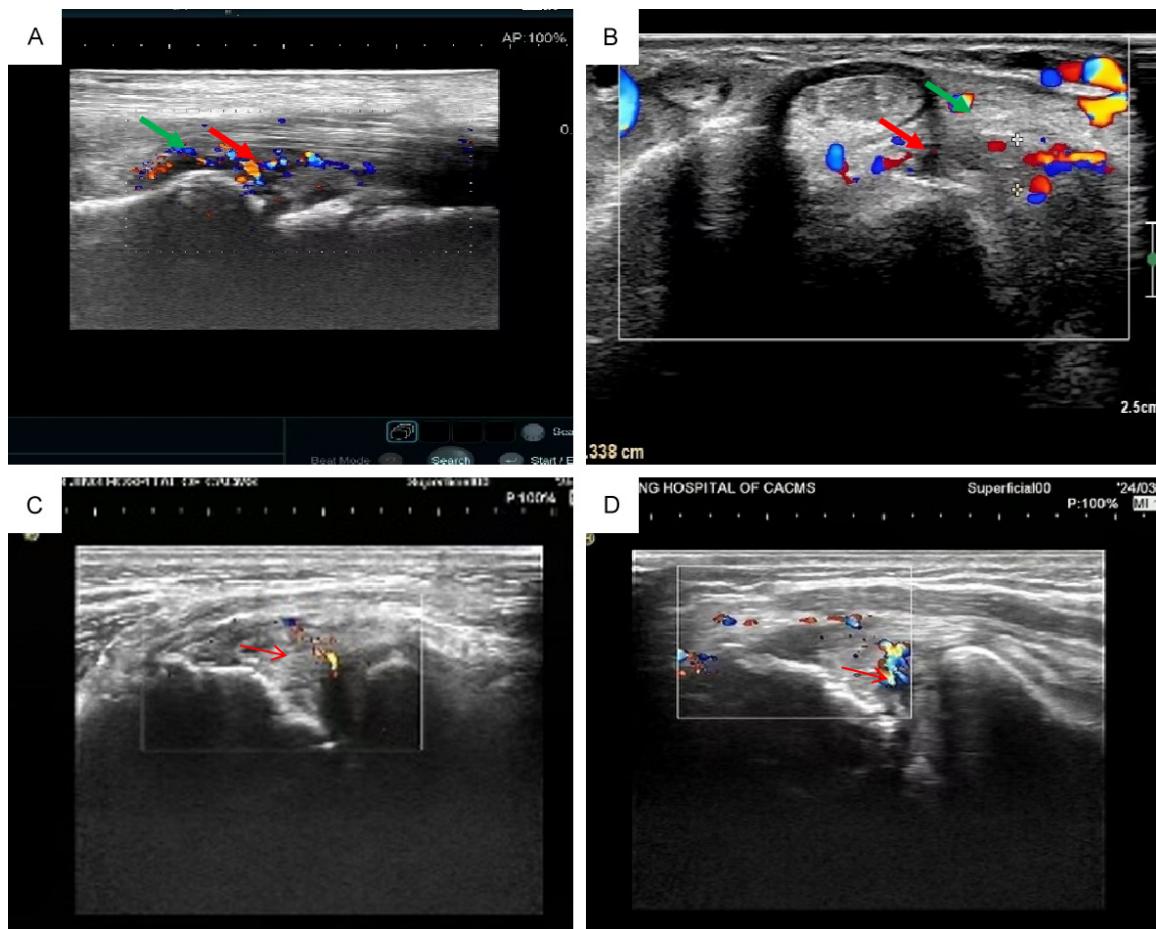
Ultrasound changes of the knee joint before and after treatment in two groups. Patient A: A. Synovial membrane thickening and grade 2 synovial blood flow signal before conventional treatment. B. Reduced synovial thickness and grade 1 blood flow signal after conventional treatment. Patient B: C. Synovial membrane thickening
